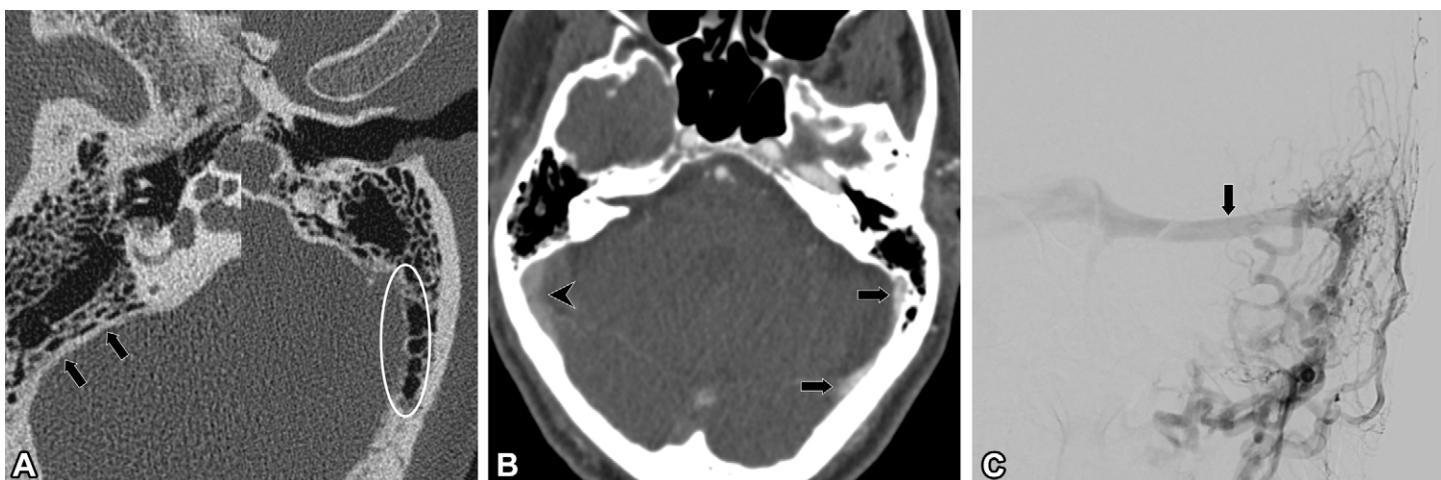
Left dural arteriovenous fistula in an 80-year-old patient with left-sided pulsatile tinnitus. (A) CT image of the temporal bone shows subtle irregularity of the left sigmoid sinus wall (oval). The normal right sigmoid sinus wall is shown for comparison (arrows). (B) Axial image from subsequent CT angiography shows asymmetric enhancement of the left transverse and sigmoid sinuses (arrows) relative to the right transverse and sigmoid sinuses (arrowhead). (C) DSA image shows a dural arteriovenous fistula with retrograde drainage into the left transverse sinus (arrow). Coil embolization was performed from a transvenous approach (Fig S2), and the patient's symptoms resolved.
